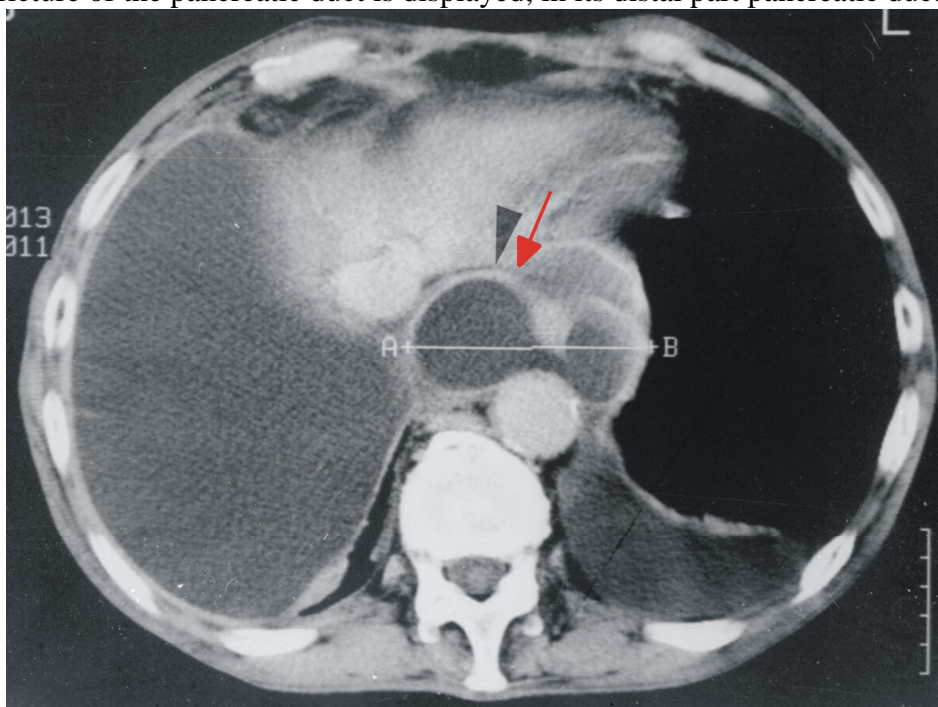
CT-- course of fistula in the mediastinum and bilateral fluidothorax.
